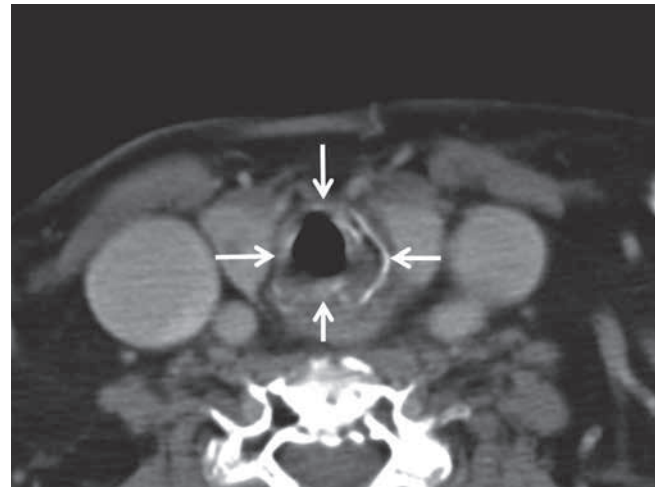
Follow-up CT study 6 months after treatment. The white arrows show a considerable volume decrease of the mass, with decrease of the subglottic stenosis.
